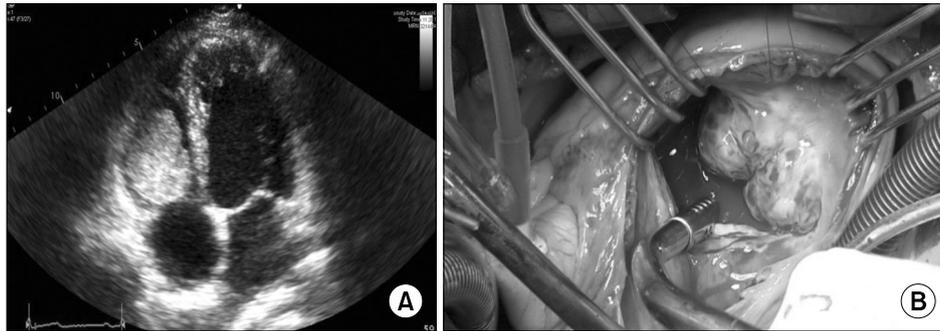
Preoperative echocardiography and intraoperative findings. (A) A transthoracic long axis view shows a mass in the right ventricle attached to the tricuspid valve. (B) Intraoperative aspect of the tumor adherent to the right ventricular free wall. The mass was attached to the ventricular surface of the tricuspid valve along the entire posterior leaflet and to one third of the anterior leaflet.
